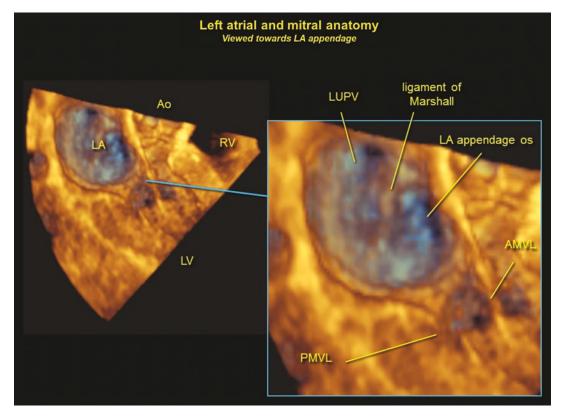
Details of the paired images presented in the previous Figure. Detailed images of the left atrial anatomy are possible using three dimensional echocardiography. *LUPV* left upper pulmonary vein
